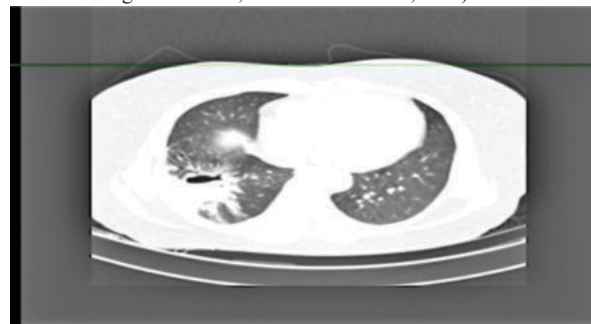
HRCT thorax showing cavitary lesion with air fluid level is noted in lateral basal segment of right lower lobe measuring 3.8X4.2X3.1 cm in size and seen to communicate with lateral segmental bronchus in this region. Area of consolidation is noted along inferior aspect of cavity. Surrounding areas of fibrosis with tractional bronchiectasis noted in right lower lobe. Laterally mass is seen to adjacent to an encysted pleural effusion measuring 4.4X1.6 cm with thickening and enhancement of adjacent pleura
